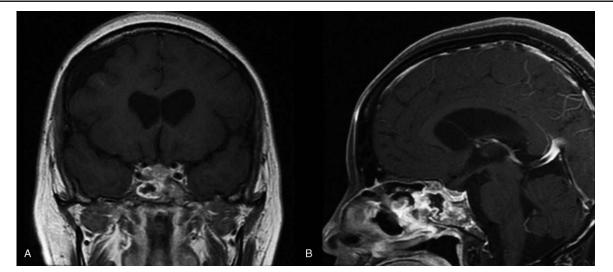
Magnetic resonance imaging (MRI) features of the pituitary 9 months after the initial transsphenoidal surgery. MRI was performed when the patient presented with typical signs and symptoms of recurrent meningitis on December 2016. Postgadolinium coronal (A) and sagittal (B) MRI showed regular changes in the sellar region postoperatively without clinically significant radiographic findings.
